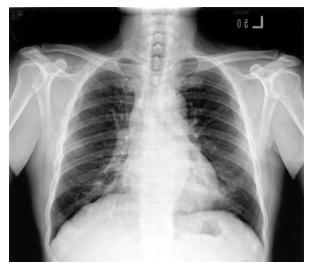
Chest X-ray film shows marked improvement 6 days after penicillin-G treatment.
